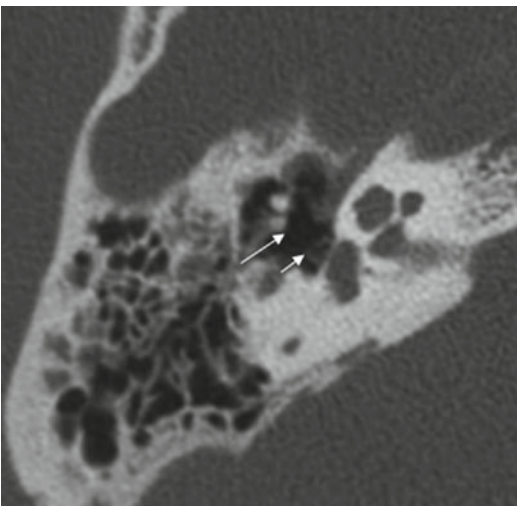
Axial computed tomographic view of a right ear showing a necrosis of the long process secondary to chronic otitis media: empty space between the intact stapes (*short arrow*) and the rest of the incus (*long arrow*)
